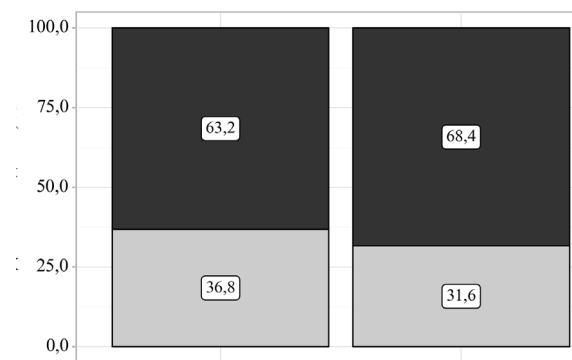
Analysis of MR differentiation of pancreatic tumor focus depending on the multiparametric MRI feature among study participants
